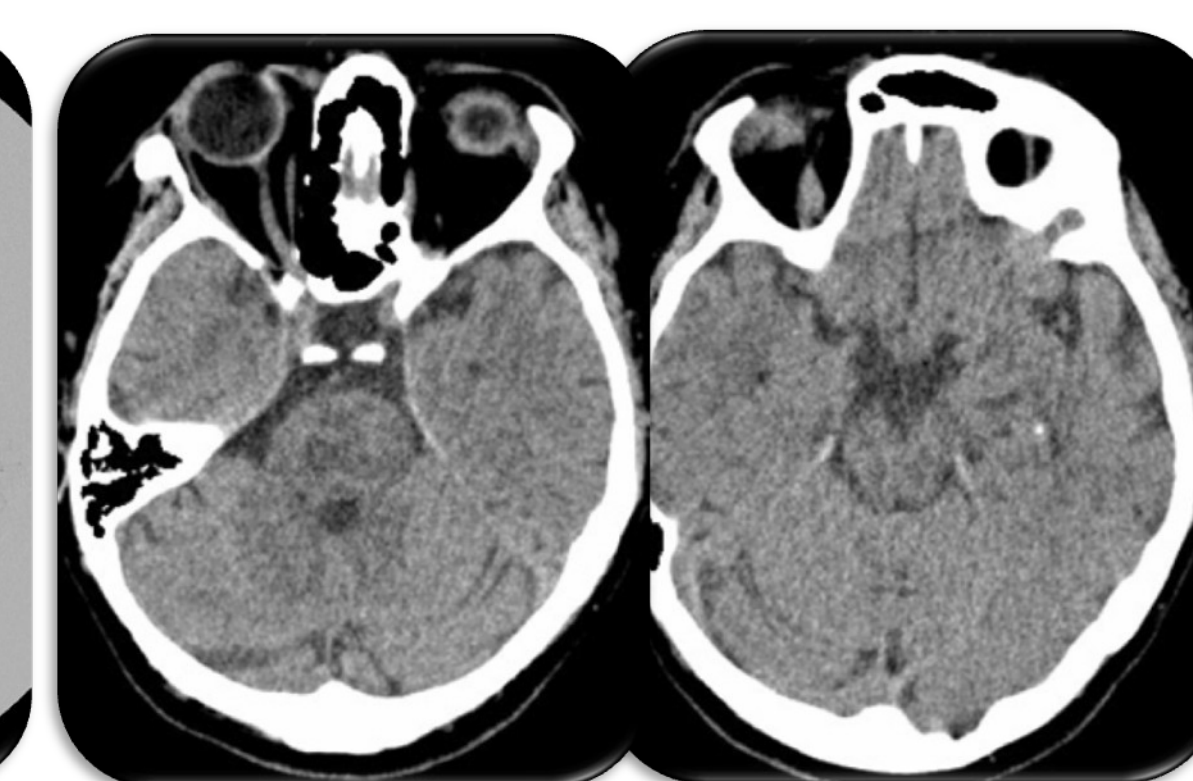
CT scan at 24 h NIHSS:2; GCS: 15
